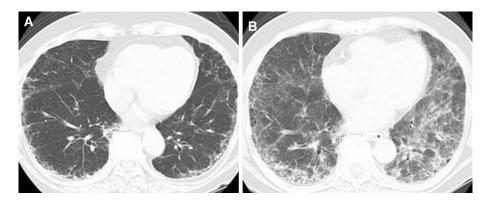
Acute exacerbation of chronic fibrosing interstitial pneumonia (IP). Chronic IP (CIP) of the usual interstitial pattern (usual IP pattern) in a 73-year-old woman with dyspnea for 2 weeks who had undergone therapy with bucillamine and salazosulfapyridine for 6 years. (A) High-resolution computed tomography (HRCT), showing patchy reticular opacity in the subpleural region before the onset of acute exacerbation. (B) HRCT, showing widespread ground-glass opacity that overlaps pre-existing shadow at the onset of lung disease within 1 month. Her rheumatoid arthritis was poorly controlled, and she did not change medicine at the onset of signs. A diagnosis of acute exacerbation of CIP was more likely than drug-induced lung injury.
